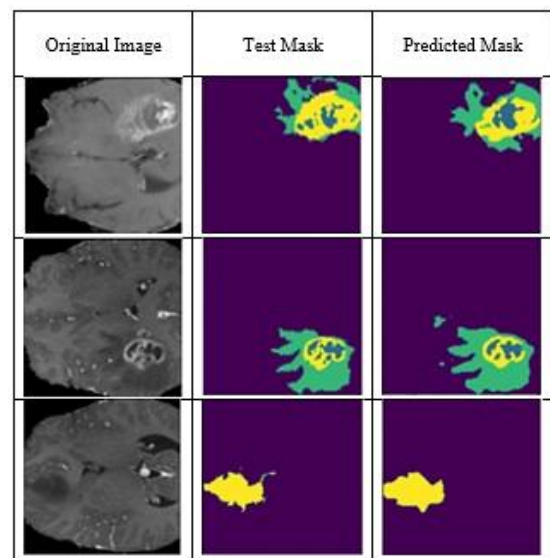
Visualized segmentation examples of MRI images
